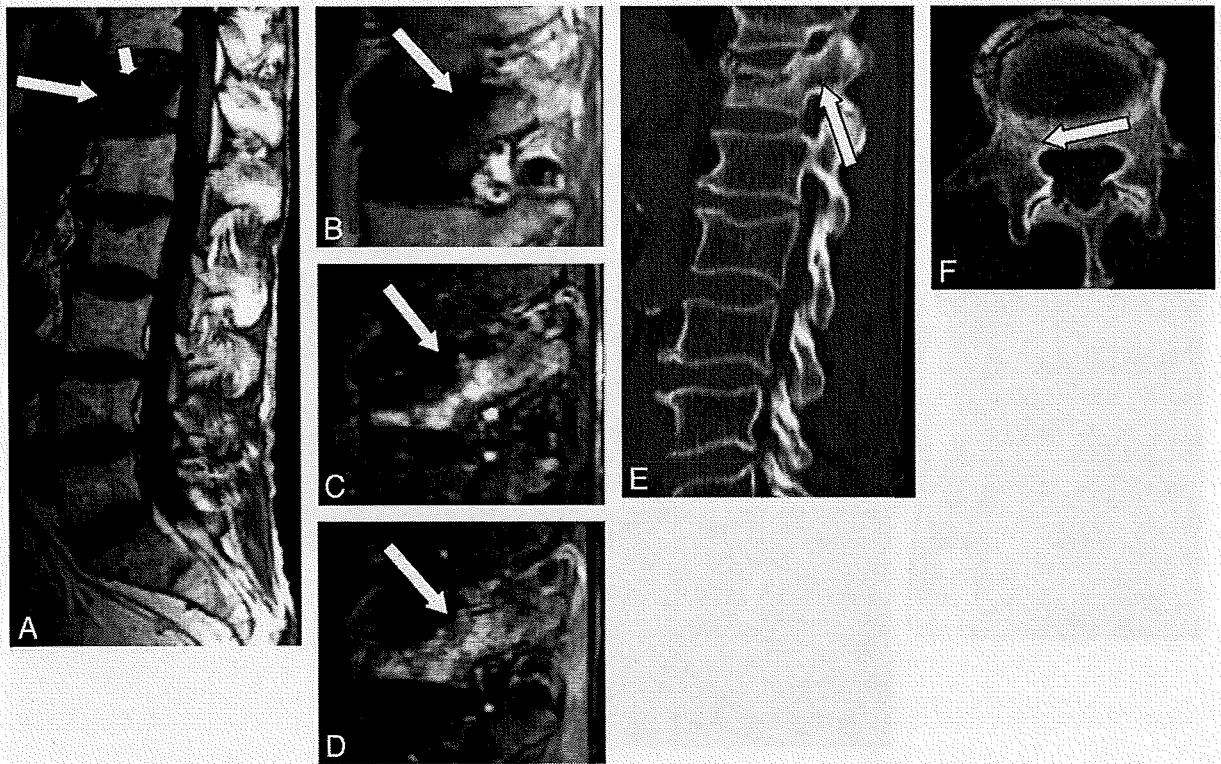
A 65-year-old man with benign compression fracture, which occurred 2 months earlier. *A* and *B*, T1WI shows diffuse hypointensity in the vertebral body and the right pedicle of T12 (arrow). There is a marked hypointensity band adjacent to the superior endplate, indicating a gas cleft (small arrow). *C*, STIR image shows heterogeneous hyperintensity in these areas (arrow). *D*, Contrast-enhanced T1WI shows moderate enhancement in the vertebral body and in the right pedicle (arrow). *E* and *F*, On sagittal (*E*) and axial (*F*) CT scans, sclerosis is seen around the gas cleft including the base of the right pedicle (arrow).
